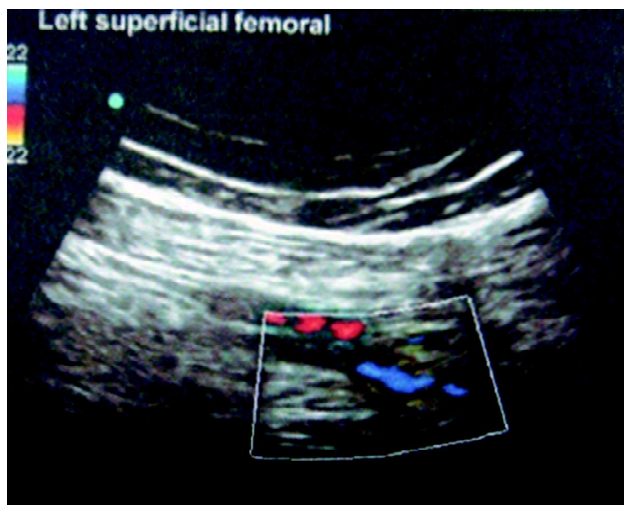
Arterio-venous doppler of left lower limb after anticoagulation showing recanalisation of left superficial femoral vein with good flow.
